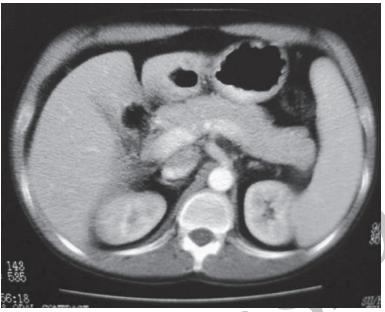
Abdominal CT scan six month later did not reveal any mass lesion in the head of pancreas.
